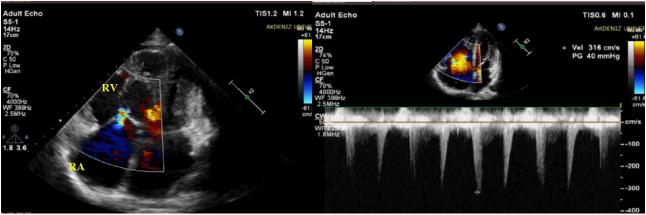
On echocardiography performed at the 3rd month following discharge, mild tricuspid regurgitation and measurement of PAB as 65 mmHg.
